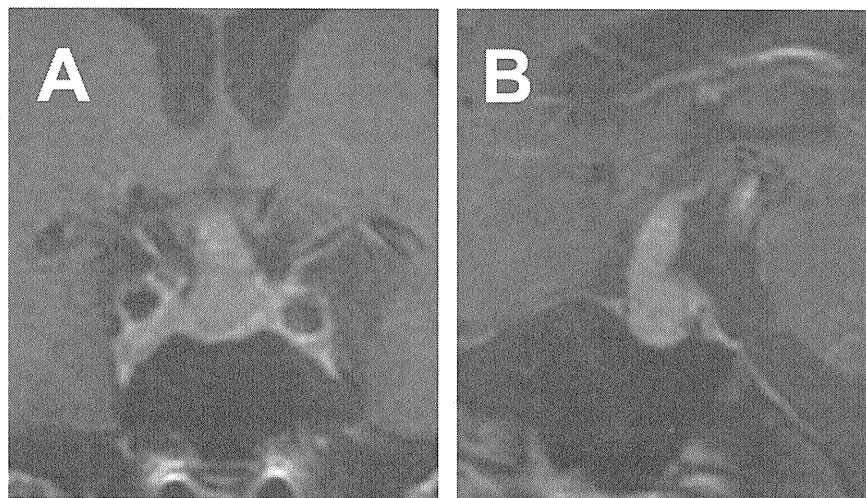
MR imaging of the pituitary in a patient with IgG4-related infundibulo-hypophysitis [33]. T1-weighted gadolinium enhanced imaging (A: coronal section, B: sagittal sections)
